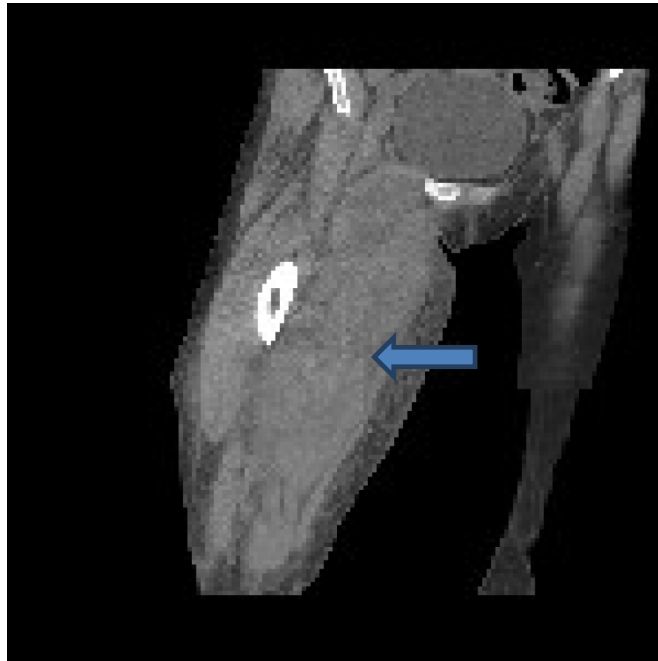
CT scan of right thigh, arrow indicating hematoma.
